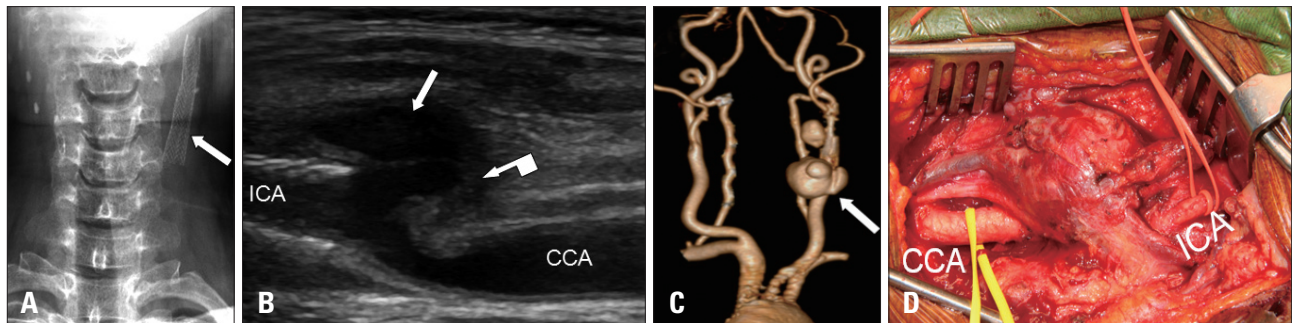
Neck X-ray showing a long left carotid stent (arrow) (A). Cervical duplex showing the pseudoaneurysm originating from distal common carotid artery (straight arrow, B). Computed tomography angiography of the neck (C). The lobulated pseudoaneurysm (arrow, C) wrapped around the carotid system (D) multiple thrombi on the wall of pseudoaneurysm (bent arrow, B) confirmed during surgery. CCA: common carotid artery, ICA: internal carotid artery.
